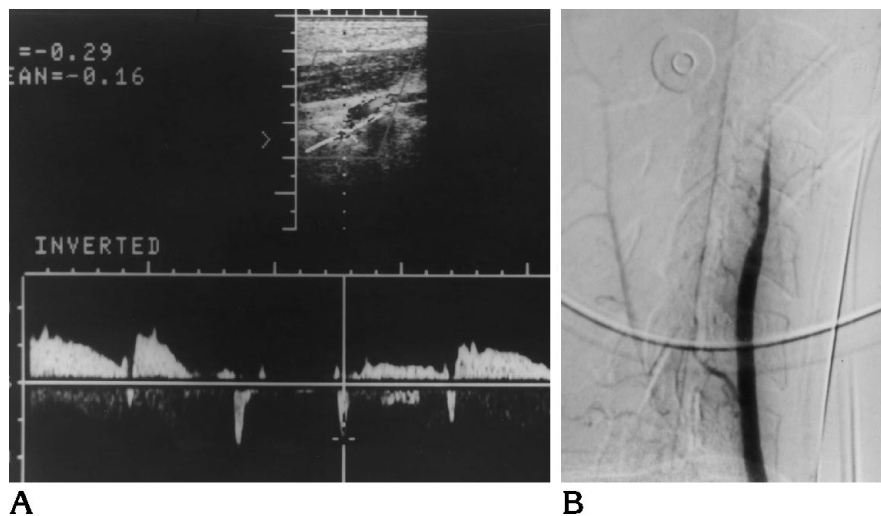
A, Pulsed Doppler sonogram of vertebral artery shows abnormal spectral pattern with cephalic and caudal flow, suggestive of a distal occlusion.
